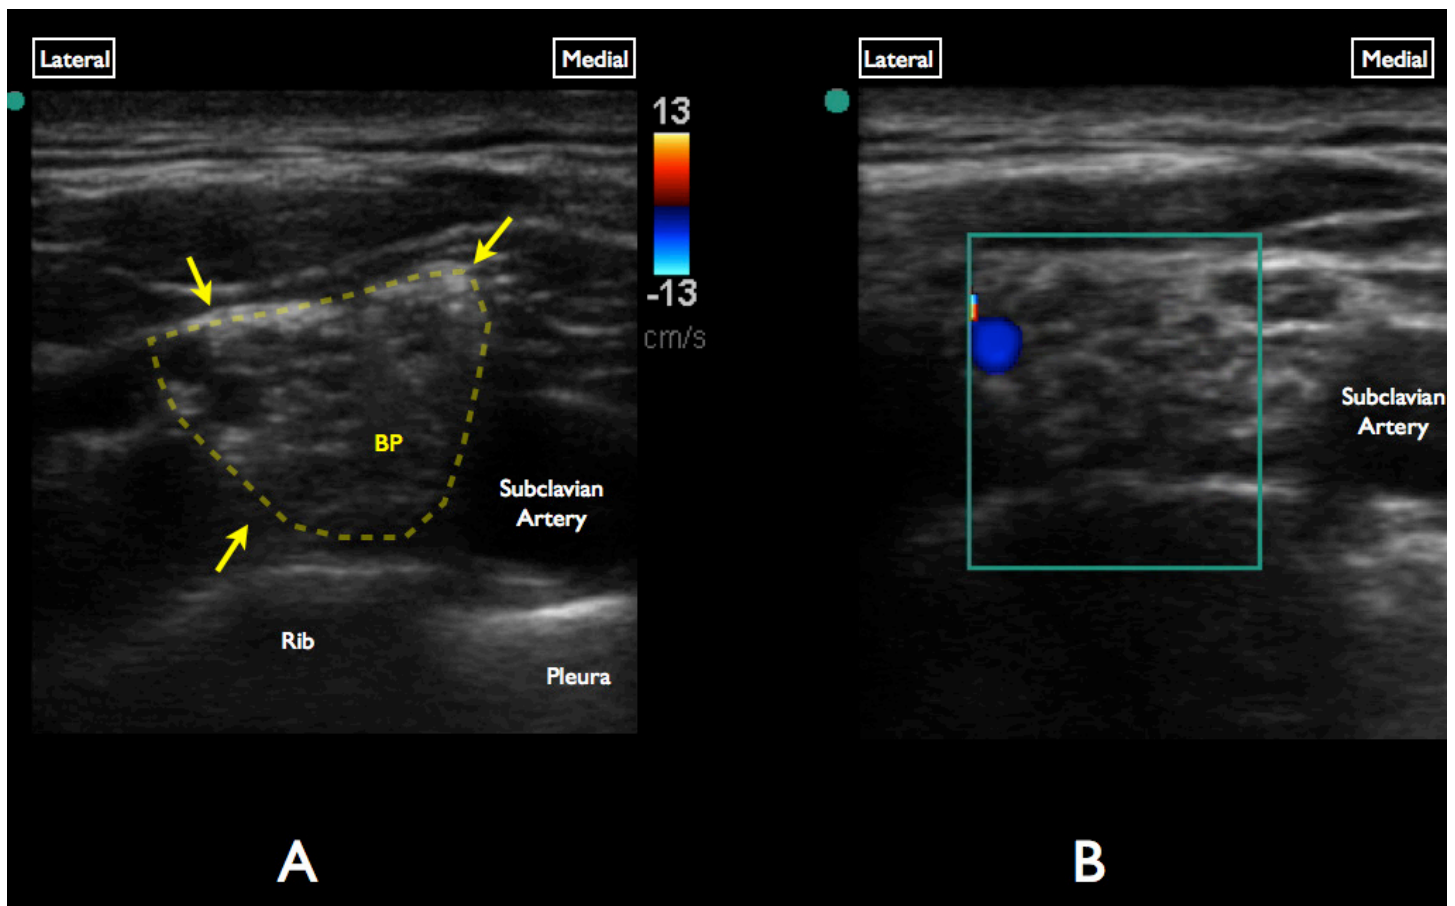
A, Gray-scale evaluation of the supraclavicular brachial plexus. Note the anechoic/circular nerve bundles (yellow arrows) lateral to the subclavian artery. B, Color Doppler interrogation of the brachial plexus demonstrates a vascular structure at the superolateral aspect of the brachial plexus.
